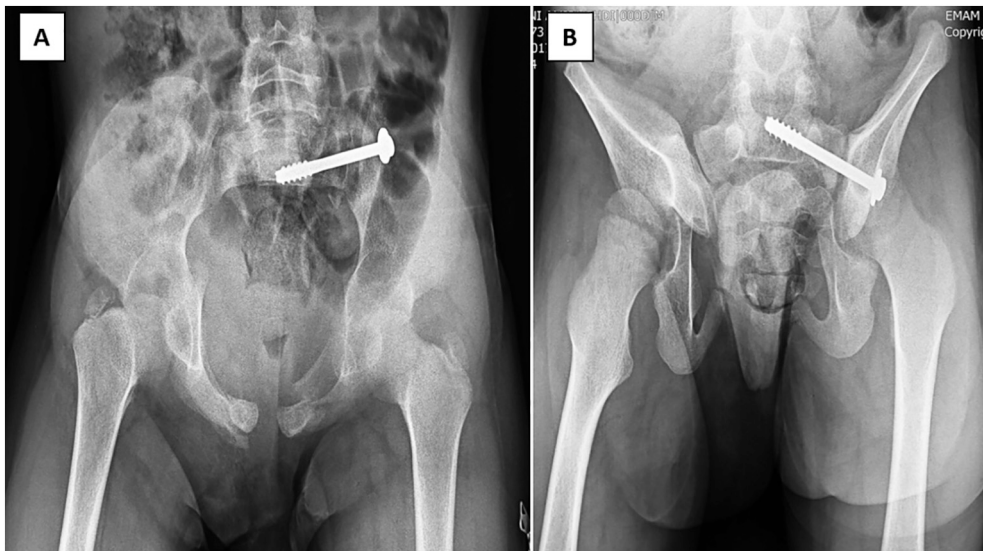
Post-op pelvic radiograph. A. Inlet view. B. Outlet view.
